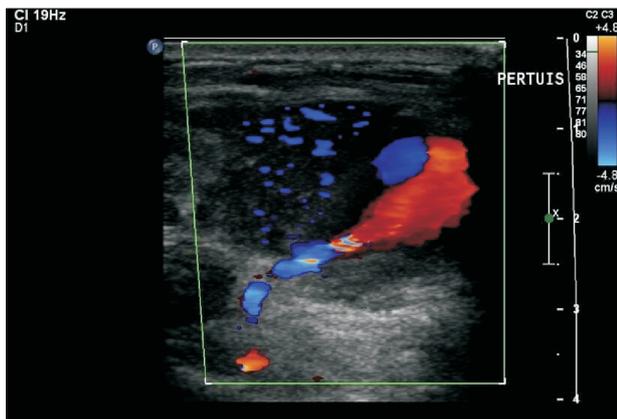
Color Doppler ultrasonography showed the parasternal well-delineated, circulating mass measuring 27 mm×31 mm×26 mm with a swirling flow within, and the track connecting the right internal thoracic artery with the false aneurysm.
